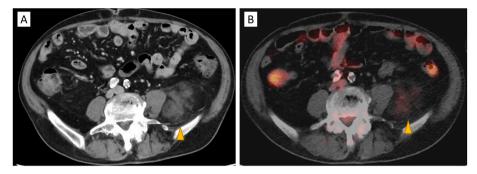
Computed tomography (A) and fluorodeoxyglucose (FDG) positron emission tomography (B) revealing a heterogeneous tumor with a macroscopic fat component and slight FDG uptake.
